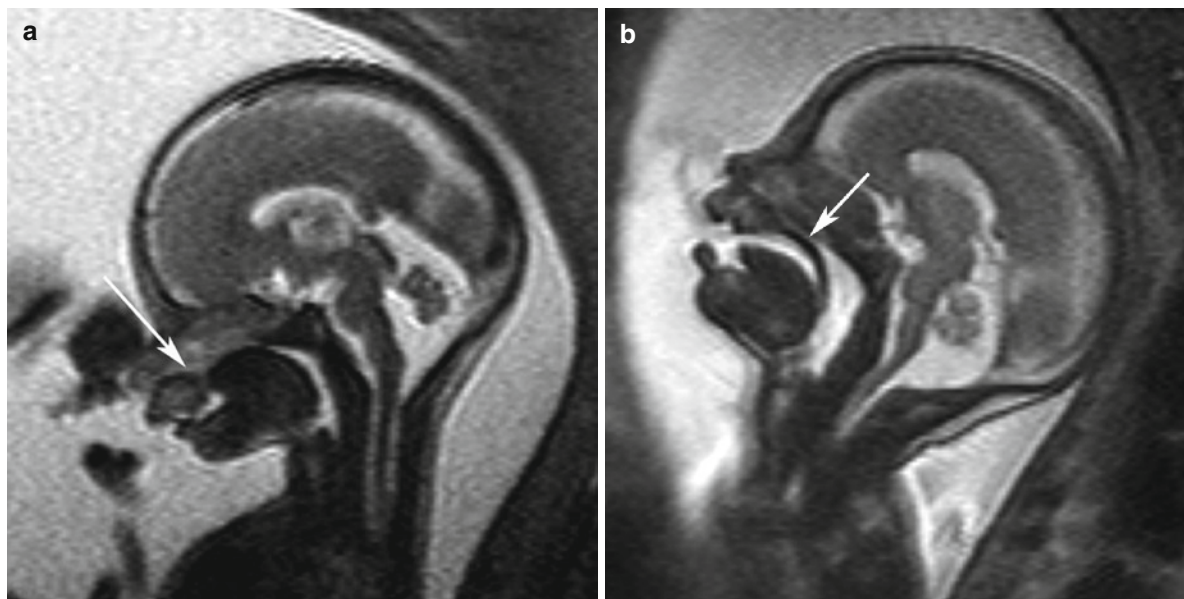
Isolated hard palate cleft. Median sagittal T2-weighted-image (a) GW 24+0, hard palate absent (arrow), (b) GW 24+1, hard palate present (arrow)
